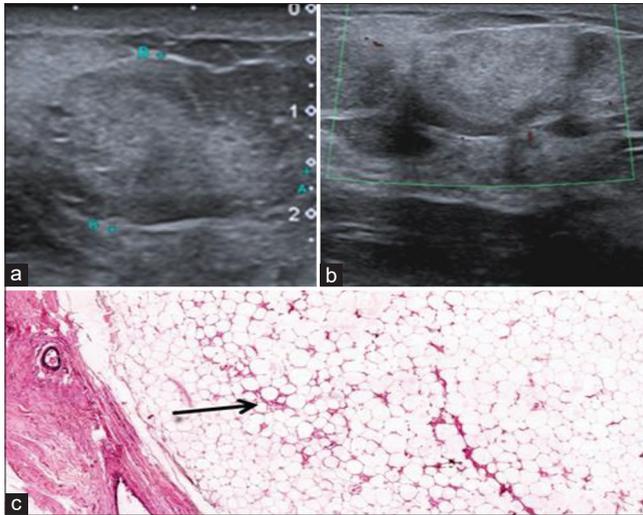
A 37-year-old female with complaints of a lump in the breast for 8 months. (a and b) Ultrasound and color Doppler image show an oval, parallel oriented, circumscribed, hyperechoic mass with few cystic changes at the periphery (arrows) with no posterior features or vascularity. (c) H & E: Well circumscribed mass with adipocytes showing fat necrosis (Black Arrow) $\times 100$
